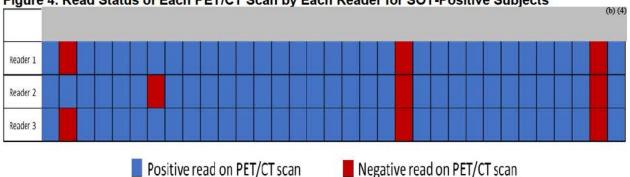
Read Status of Each PET/CT Scan by Each Reader for SOT-Positive Subjects
